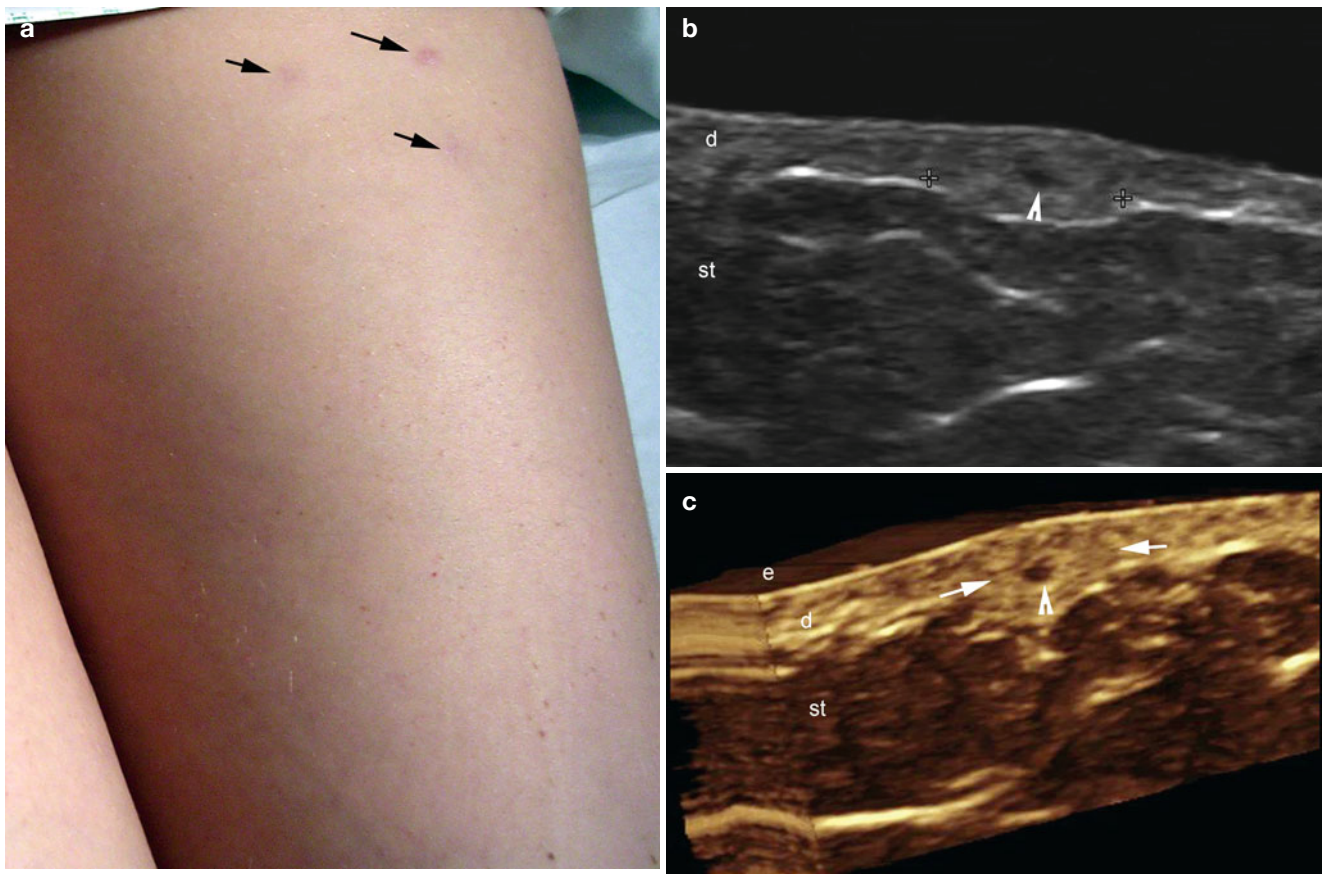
(a–c) Mesotherapy. (a) Clinical image of a patient that developed erythematous papules (arrows) in the anterior aspect of the left thigh after mesotherapy. (b, c) Grey scale ultrasound images (b transverse view; c 3D reconstruction transverse view, right upper lesion)
